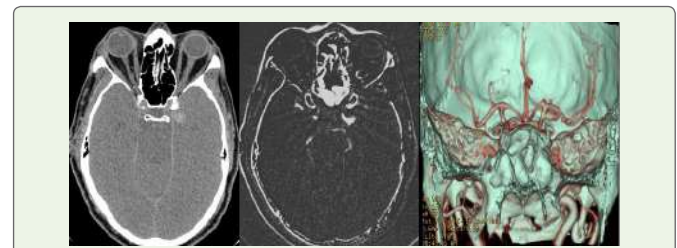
CT Noncontrast axial (A), CTCA MIP (B), and virtual dissection of the skull (C) images show a left supraclinoid ophthalmic ICA (C6) small saccular aneurysm. Endovascular therapy and routine follow-up were recommended for him.
